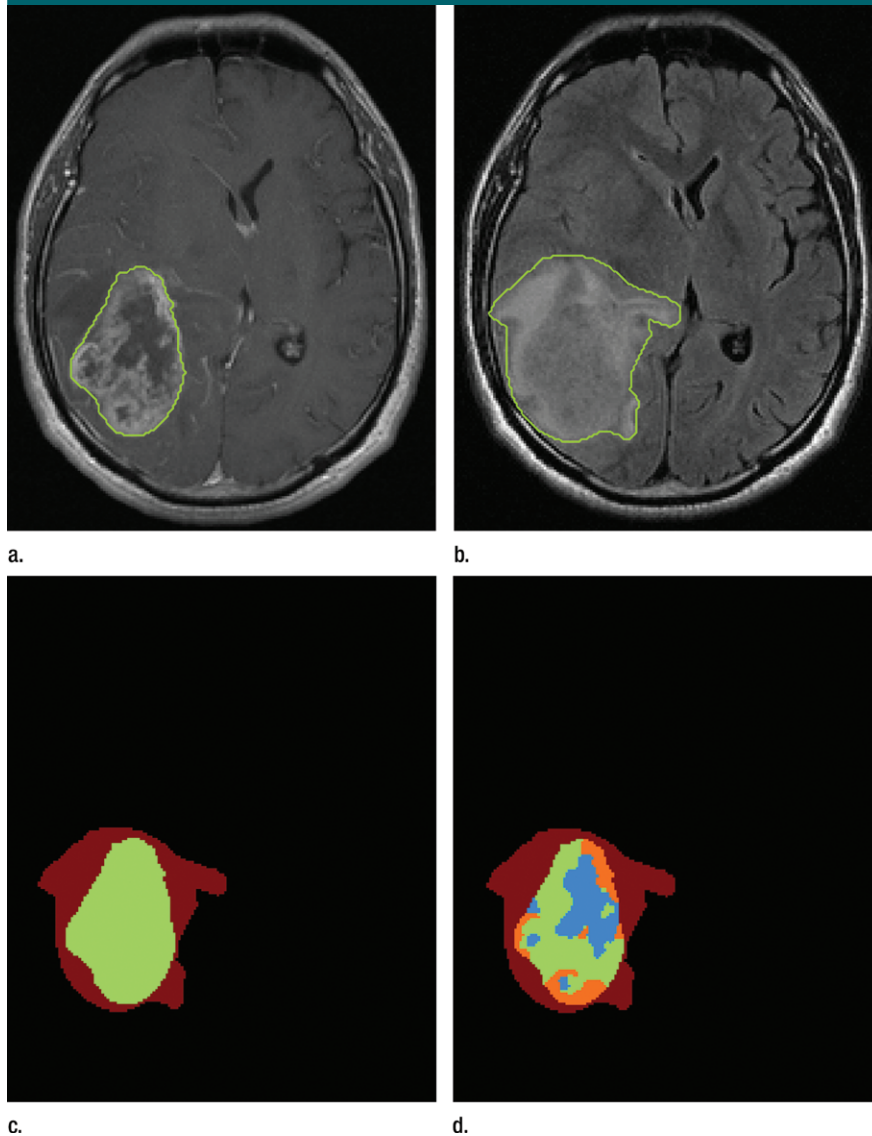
Segmentation of the delineated tumor. Delineation results in creation of (a) postcontrast T1-weighted and (b) FLAIR images. (c) Color-coded image shows tumor and peripheral nonenhancing regions. (d) Color-coded image shows the result of intratumor segmentation. Blue areas = hypointense to mildly hyperintense, green areas = moderately hyperintense, orange areas = strongly hyperintense.
